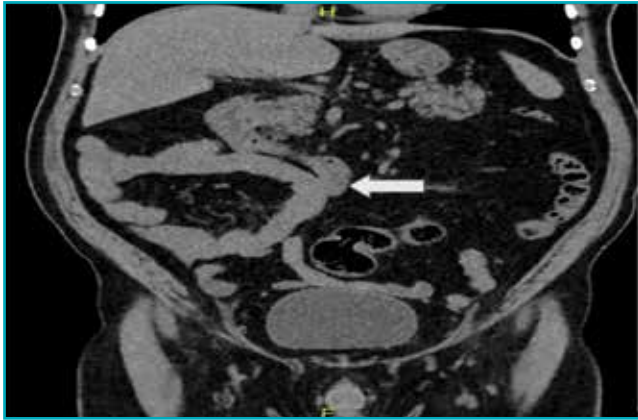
Plain coronal computed tomography (CT) image showing complete malrotation of the bowel. Jejunum loops are located on the right side of the abdomen (white arrow), while both the ascending and descending colon lie on the left.
